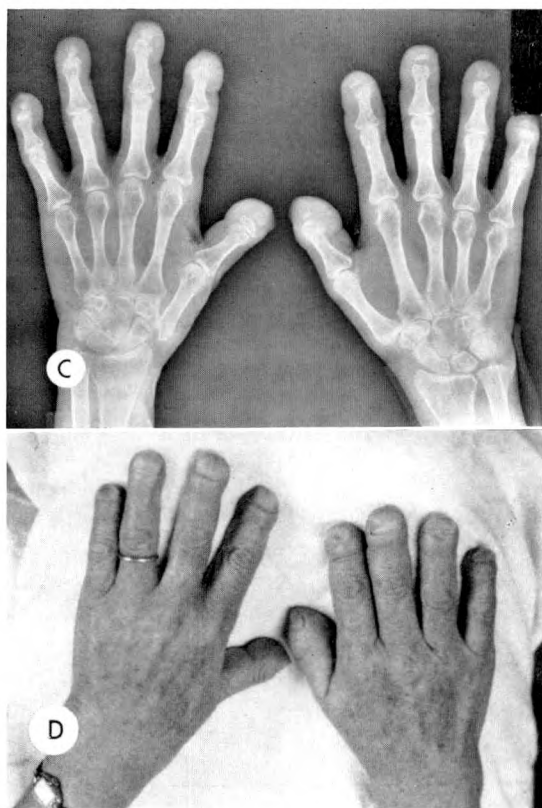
(C) Bilateral osteolysis of the terminal phalanges. (D) Soft tissues of the fingers show clubbing, but the fingernails are intact. (Courtesy of Dr. W. Whitehouse, Department of Roentgenology, University of Michigan.)
